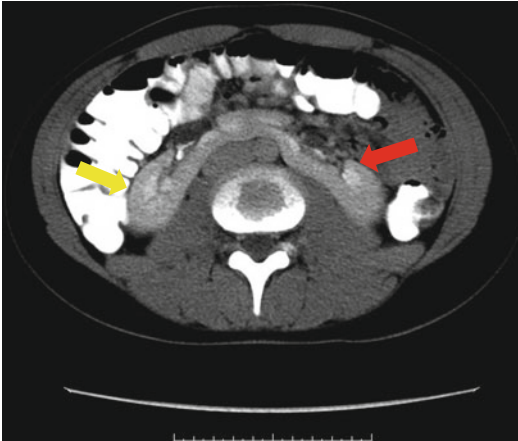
Axial CT scan view of horseshoe kidney demonstrating the right (yellow arrow) and left (red arrow) kidneys connected in the middle
